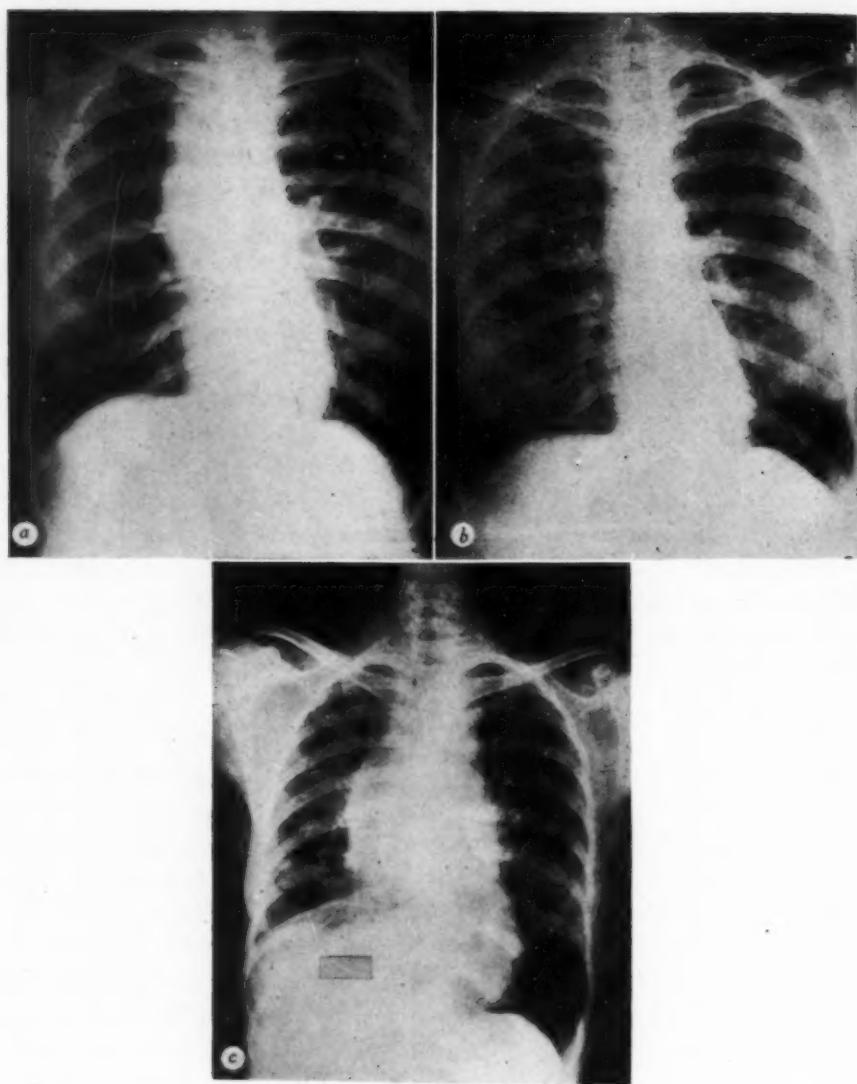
Roentgenograms of the chest in case 5.
